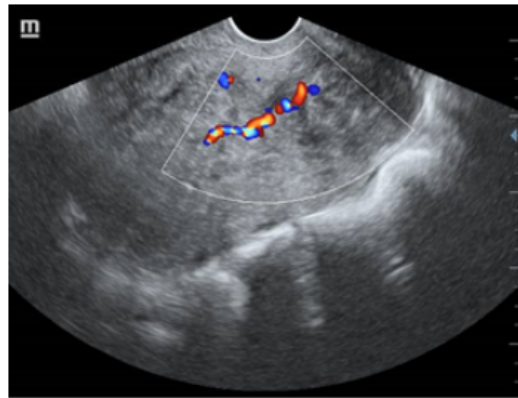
39 years old women presented with abnormal uterine bleeding. A well-defined homogenous hyperechoic lesion seen in endometrial cavity, feeding vessel on doppler it was found to be Endometrial polyp
